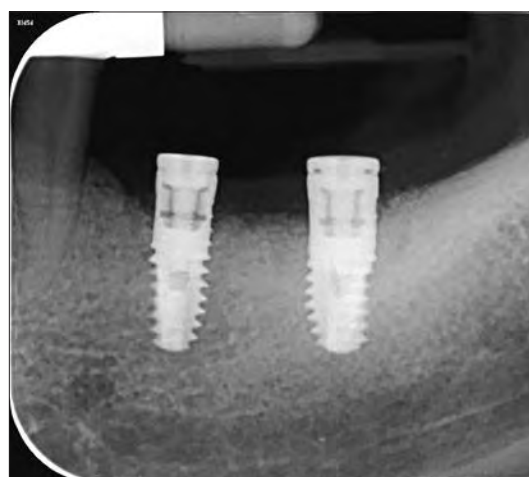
Radiographic control at 3 months: peri-implant bone levels are maintained.
